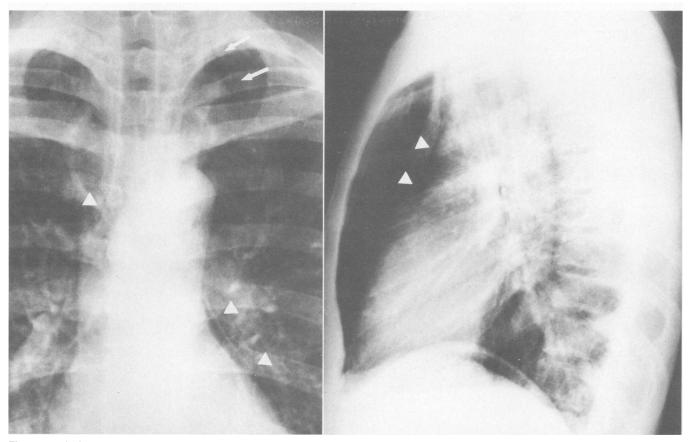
Left, anteroposterior and, Right, lateral chest radiographs show subtle pneumomediastinum (arrowheads) and subcutaneous emphysema in the neck (arrows).
